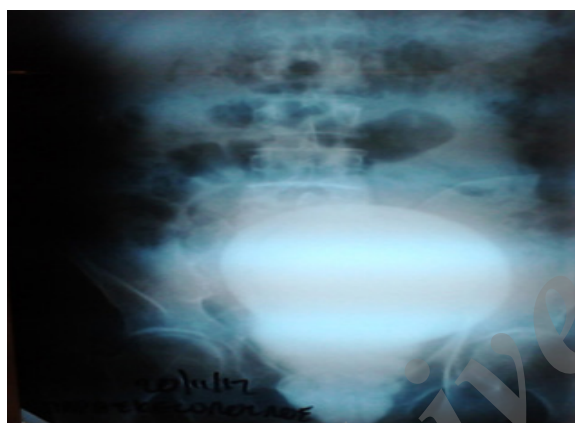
Kidney-Ureter-Bladder X-ray shows sizable vesicoprostatic stone.
